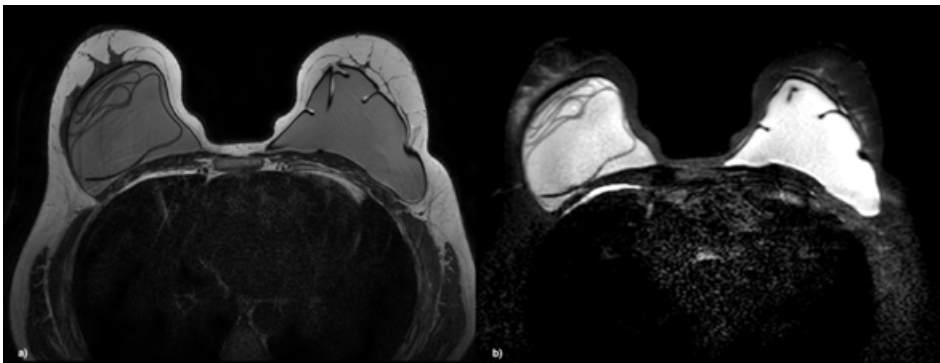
MRI study revealing the presence of the “Linguini signal”, diagnosis of intracapsular rupture, evidenced in T2 (a) and selective sequence for silicone (b).
